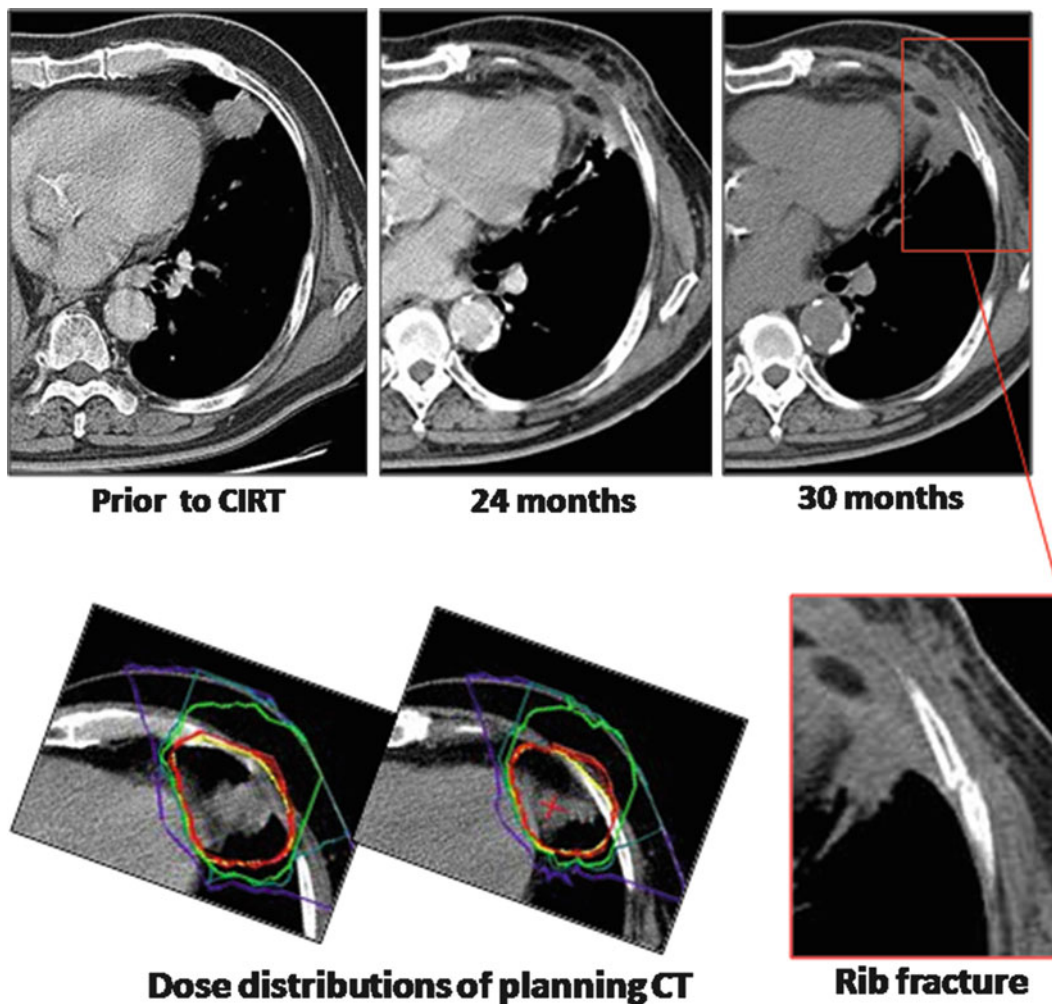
The *upper panel* shows the CT images before and after the treatment. The costal bone fracture appeared 30 months after CIRT
